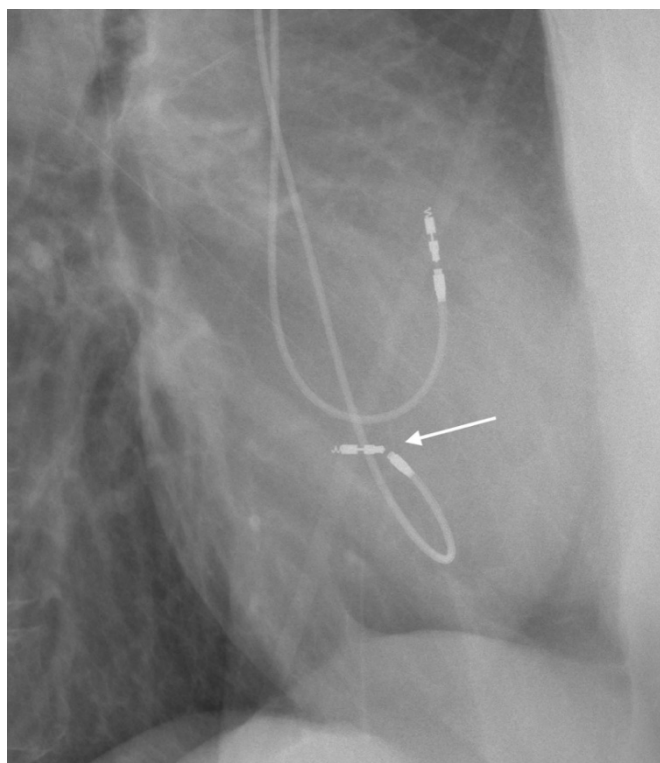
Lateral thoracic X-ray showing the fracture between tip and ring electrode (arrow)
